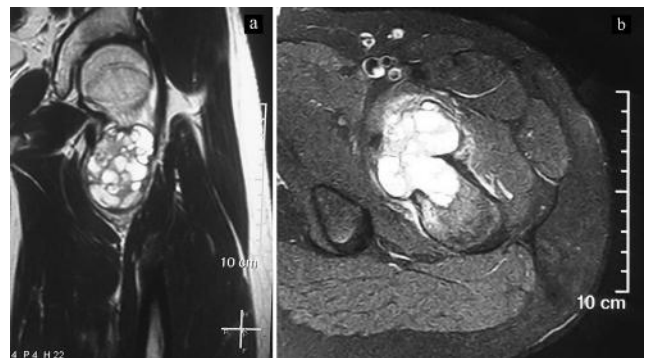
MRI of the hip shows area of signal changes involving lesser trochanter affected by well demarcated expansile lytic bone cyst on sagittal view in 3a and perilesional oedema with soft tissue displacement on axial view in 3b
